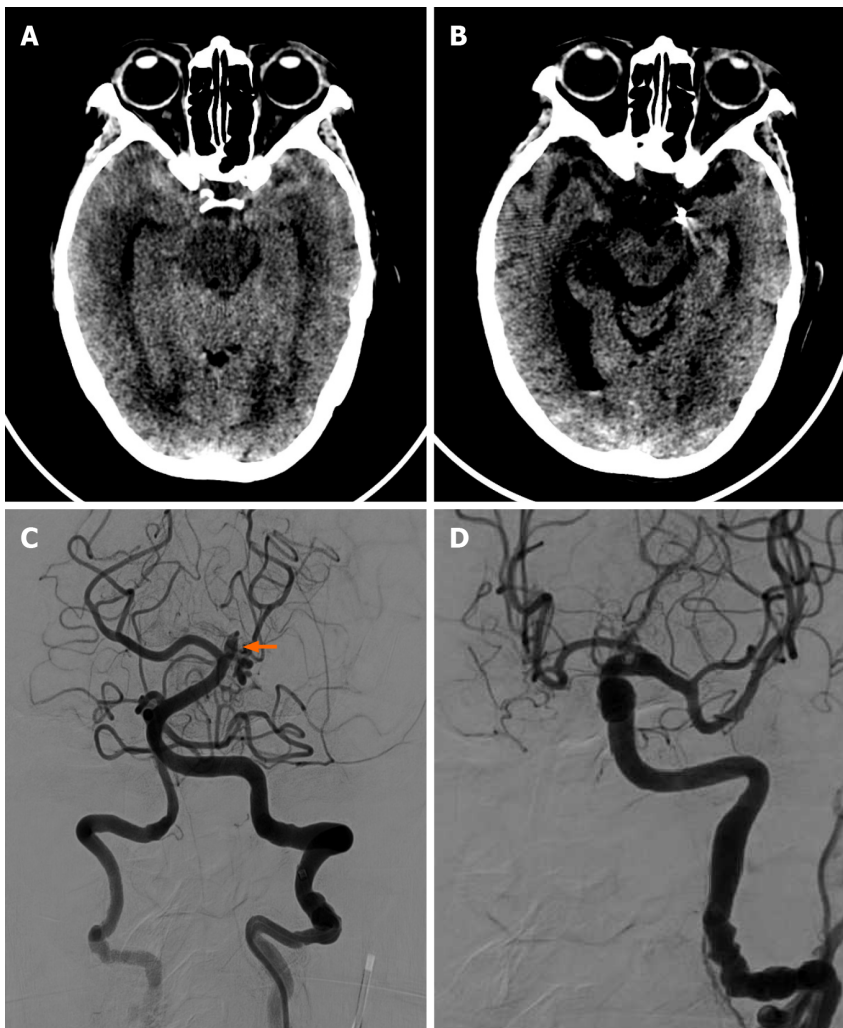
Case 2. A: Axial brain computed tomography of a 79-year-old female showed bilateral subarachnoid hemorrhage in the bilateral temporal region; B: Axial brain computed tomography post-treatment showed the previous subarachnoid hemorrhage in the bilateral temporal region had subsided. No intracranial hemorrhage was found; C: Angiography showed a bulging aneurysm in the basilar perforated branches; D: Final angiography showed complete embolization of the aneurysm.
